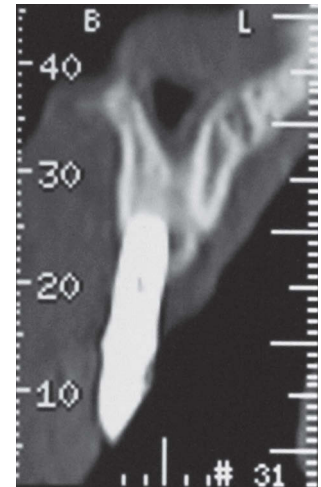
Radiographic and tomographic initial images of the clinical case.
